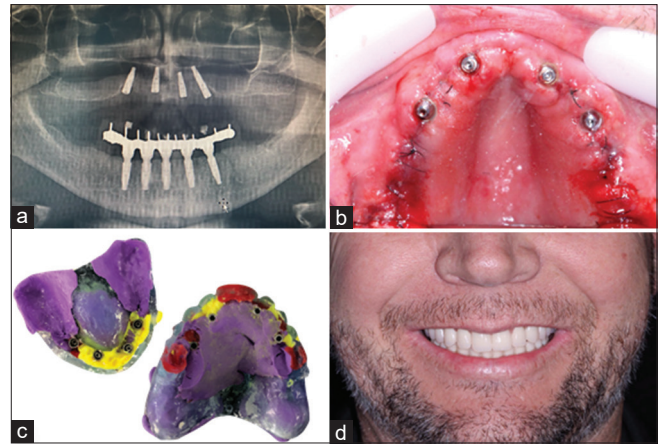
(a) Panoramic radiography after implant placement. (b) Postoperative picture: after positioning the prosthetic components. (c) Multifunctional guide with shaping material and occlusal registration after capturing the transfer of the prosthetic components positioning. (d) Setting of acrylized final prosthesis
